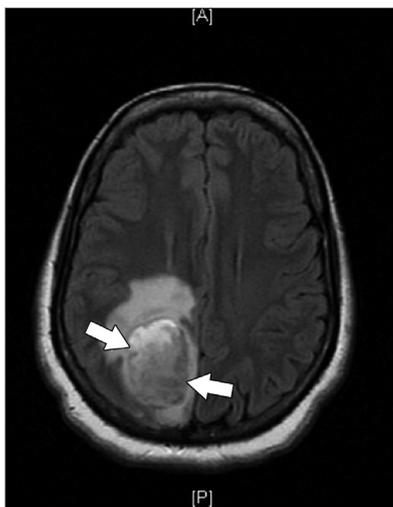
Brain MRI shows large right posterior parietal lesion (ring enhancing lesion) (arrows).
